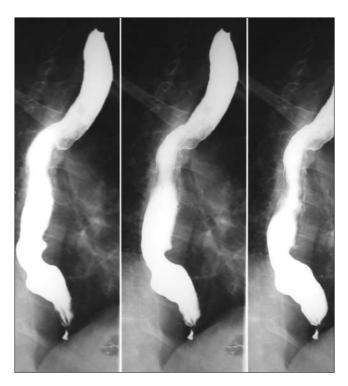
Barium radiographic study showing an air-fluid level, and a dilatation in the distal oesophagus
